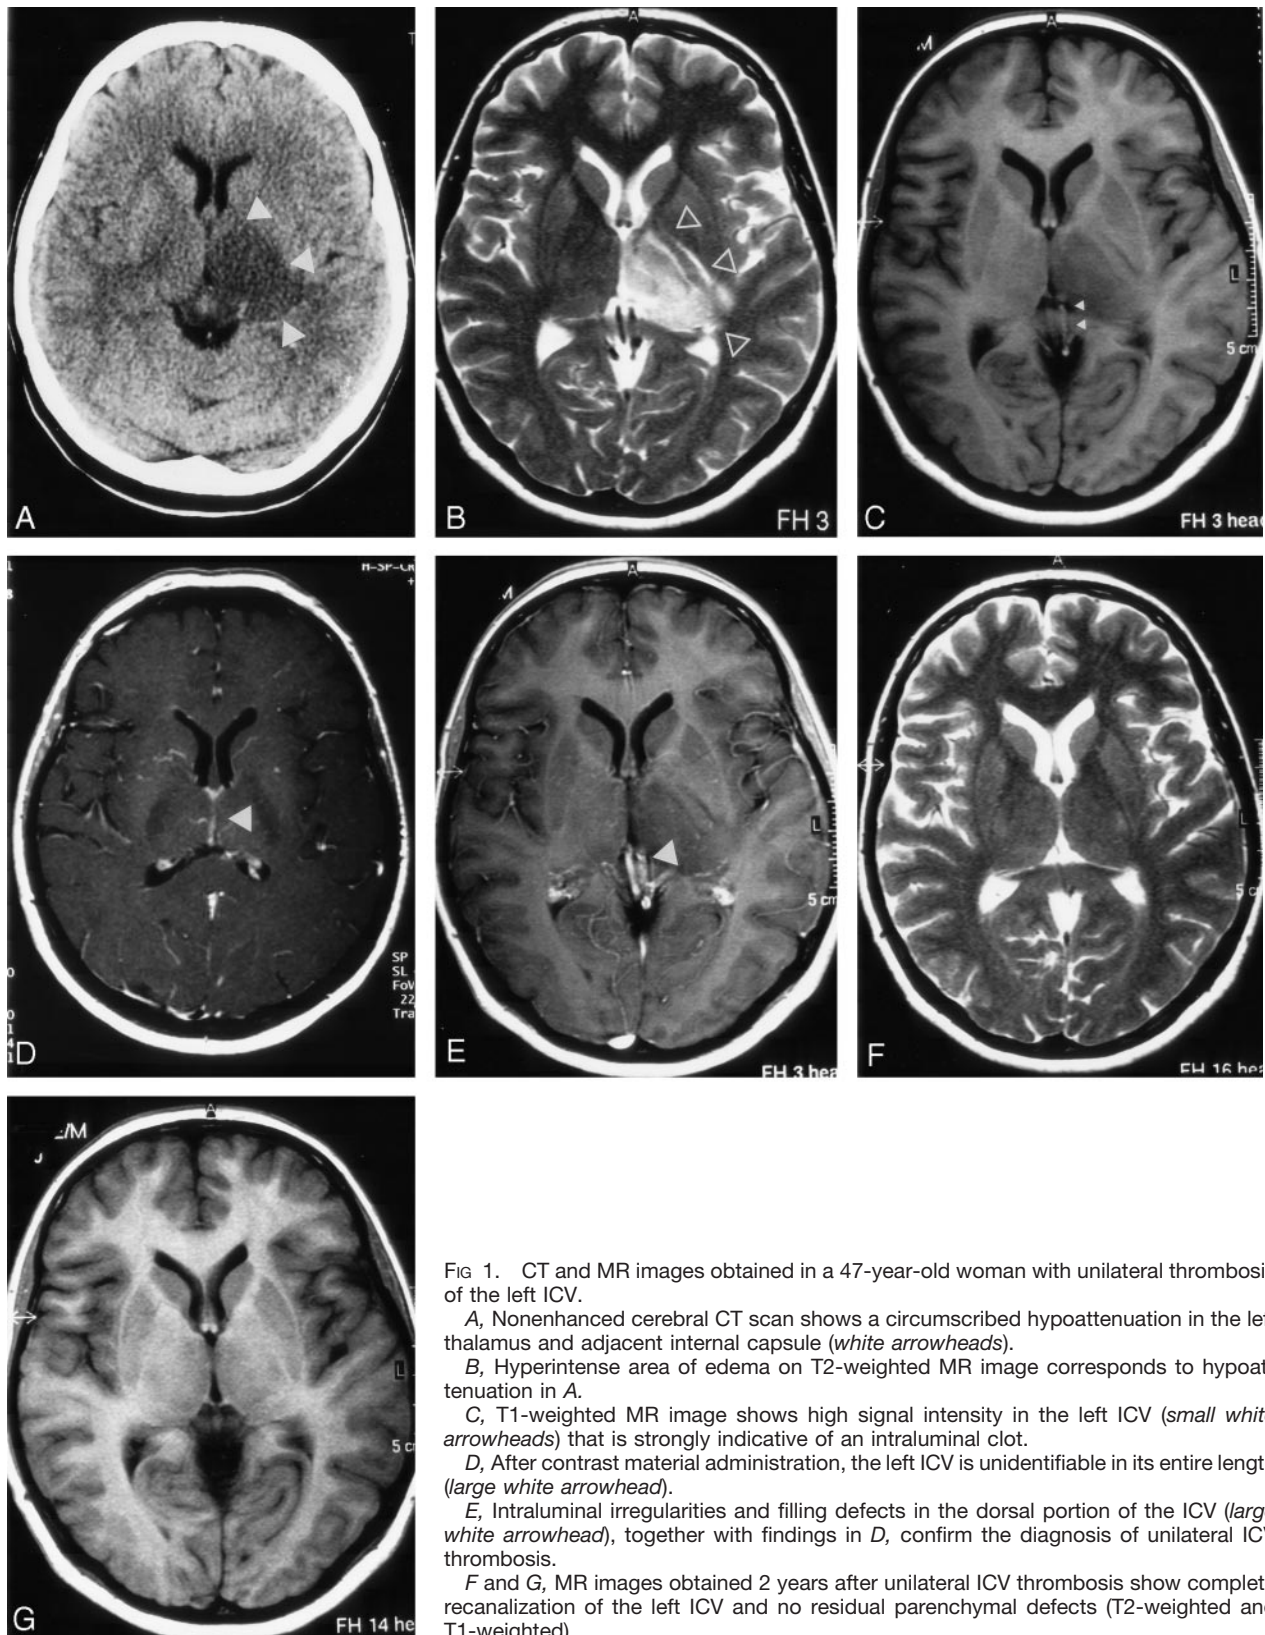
CT and MR images obtained in a 47-year-old woman with unilateral thrombosis of the left ICV.
